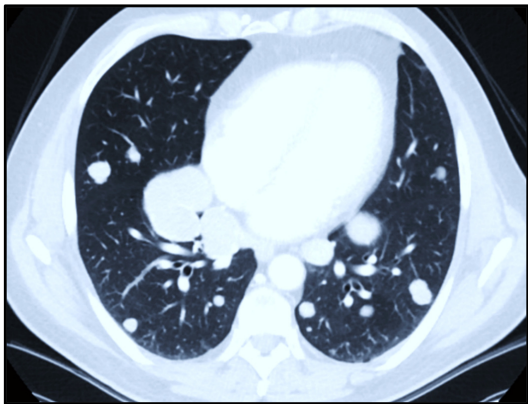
Contrast-enhanced CT scan showing multiple bilateral lung metastatic nodules.
